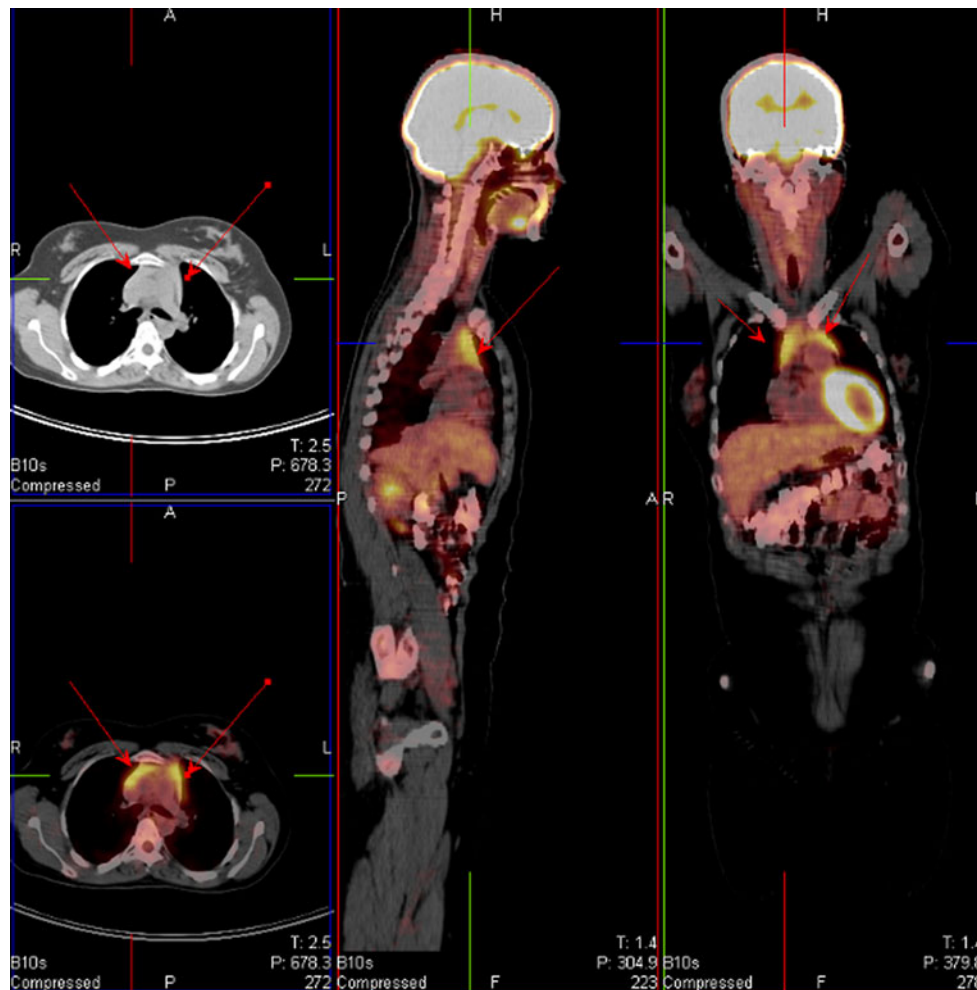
The anterior mediastinal mass on the CT and PET-CT scan (transaxial, vertical and coronal sections) of a patient with Hodgkin's lymphoma 4 months after chemotherapy indicating thymic hyperplasia
